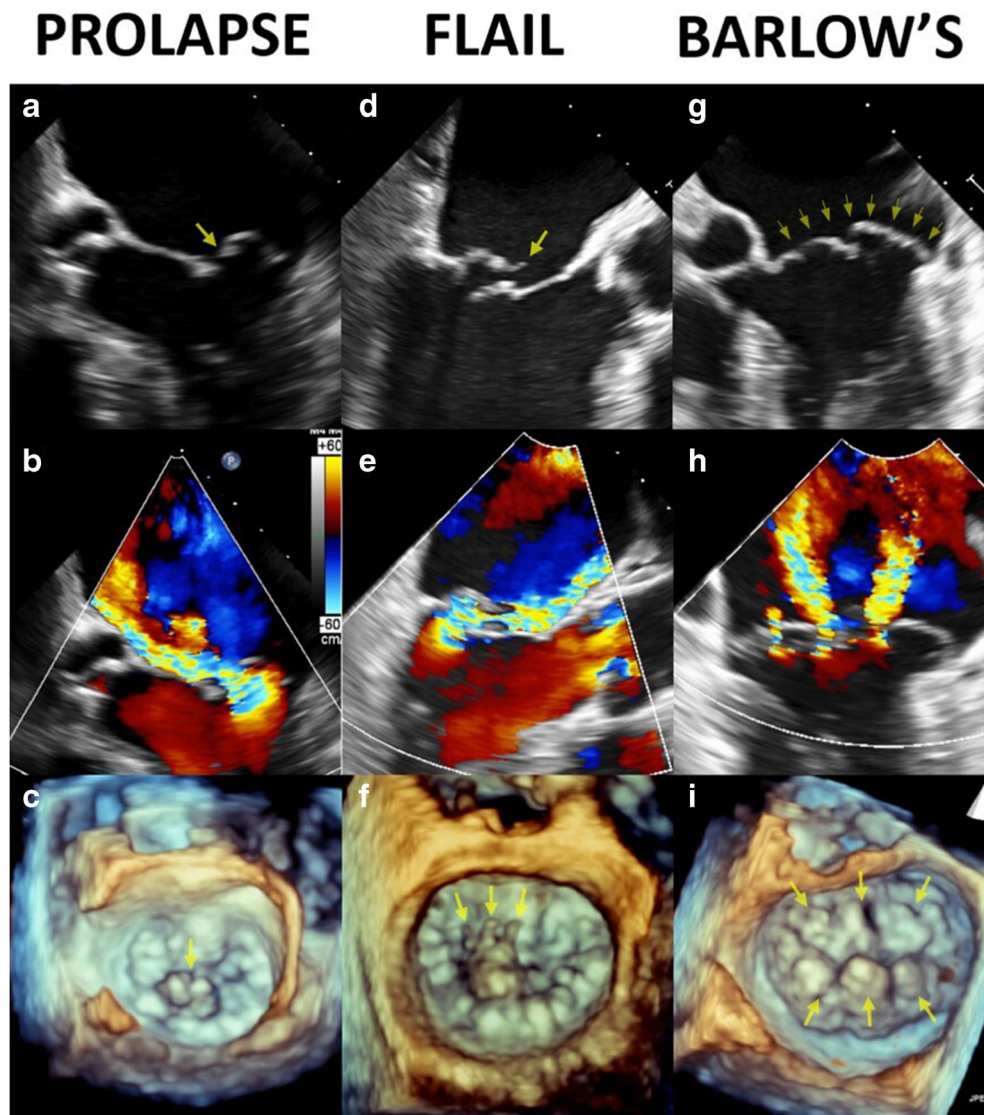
Spectrum of DMR. DMR types as seen on transesophageal echo. Top row: 2D long axis views of the mitral valve; middle row: same views with color flow Doppler; bottom row: 3D volume-rendered images of the mitral valve in the surgeon’s view (aortic valve on top). Focal leaflet prolapse (a–c, arrows), the milder form of DMR, is characterized by systolic billowing of the leaflet(s) above the plane of the mitral annulus. A flail leaflet (d–f, arrows) is caused by ruptured chordae tendineae. Remnants of the torn chordae can be seen on 3D echo (f, arrows). Barlow’s disease is the diffuse form of DMR affecting all scallops of both mitral leaflets (g–i, arrows) and frequently associated with multiple jets of MR (h).
